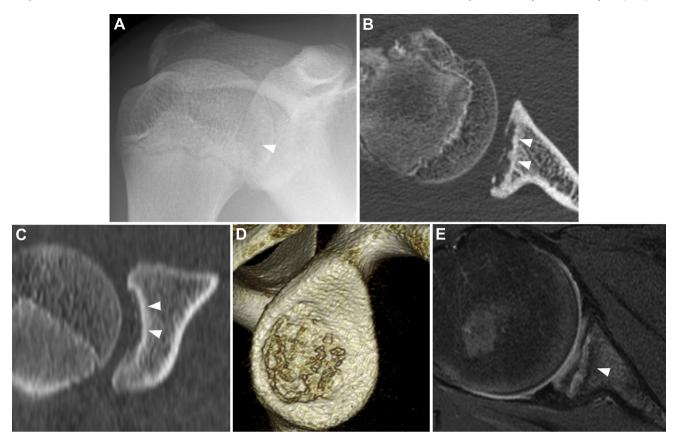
Anteroposterior radiograph of the right shoulder showed a translucent sign (*arrowhead*) in the glenoid (A). Computed tomography (B, C, D) showed a defect (*arrowheads*) in the bone of the glenoid. Axial T2-weighted magnetic resonance imaging (E) demonstrated a high intensity area (*arrowhead*) in the subchondral bone of the glenoid.
